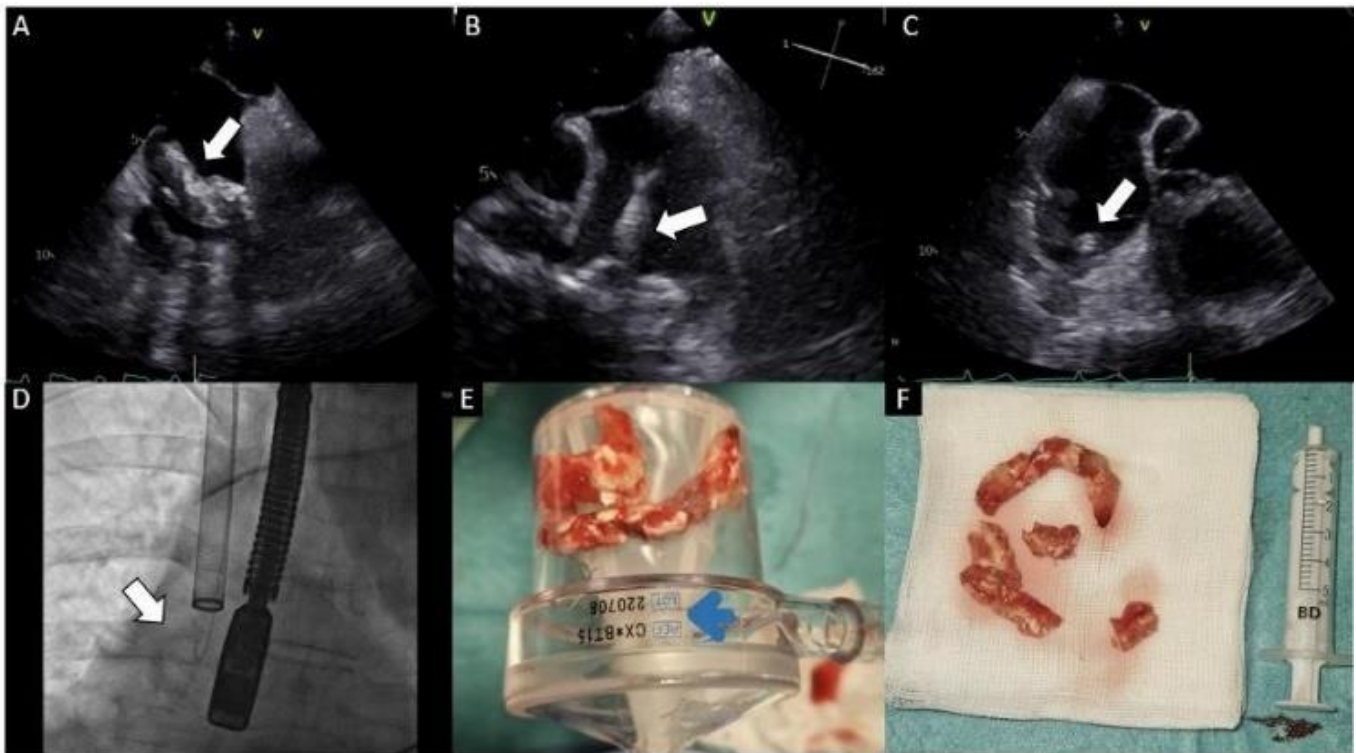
A: A transesophageal echo cardiography (TEE) showing a mobile structure (arrow) in the right atrium (RA) of 5.1 x 2.0 cm in size posing a risk for pulmonary artery embolization; B: An expandable funnel-shaped distal tip of the AngioVac Cannula (arrow) aspirating the RA structure with the suction forces generated by the extracorporeal circulation; C: The TEE showing the remaining pedunculated structure in the RA; D: Fluoroscopy Showing the introduction of the AngioVac Cannula (arrow) to the RA structure via left femoral vein and the TEE; E: An extracorporeal circulation filter showing removed thrombus; F: Thrombotic materials removed by AngioVac.
